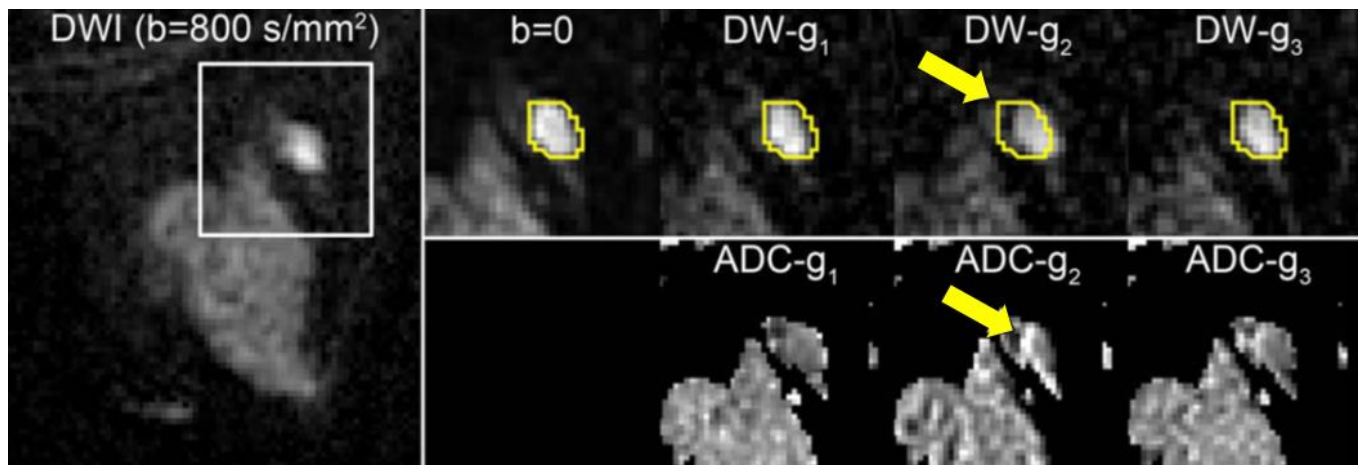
Spatial misregistration between images within a DWI sequence representing eddy-current artifact. A breast lesion is visible in the lateral breast on the averaged DW image ( $b=800$  s/mm<sup>2</sup>, left). White box shows region of magnification. A contour of the lesion defined on  $b=0$  and propagated to the individual gradient direction DW images for the same slice shows the lesion is shifted (arrow) in the DW- $g_2$  image (obtained with diffusion gradients applied in the  $g_2$  direction) with respect to the  $b=50$  s/mm<sup>2</sup> image and other  $b=800$  s/mm<sup>2</sup> images (obtained with gradients in the orthogonal  $g_1$  and  $g_3$  directions), owing to eddy-current effects. This misalignment causes an artifactual increase in ADC at the edge of the lesion on the corresponding ADC map (below). (Figure adapted from Partridge et al., J. Magn Reson Imaging 2017;45:337–355 [111])
